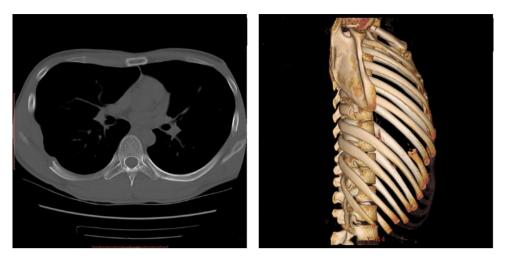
Postoperative CT 3D reconstruction shows that the rib tumor has been completely removed.
